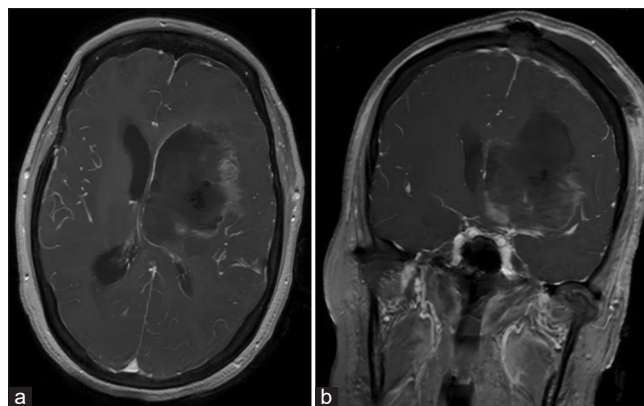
(a) Axial T1-weighted contrast-enhanced magnetic resonance (MR) image obtained 3 weeks before surgery. The lesion measures  $4.2 \times 4.5$  cm. (b and c). Axial T1-weighted contrast enhanced MR image obtained 3 weeks after the MRI in (a). The tumor measured grew to  $6.3 \times 5.5$  cm. All three tumors are visible in (c and d). Coronal T1-weighted contrast-enhanced MR image obtained 3 weeks after the magnetic resonance imaging in (a).
